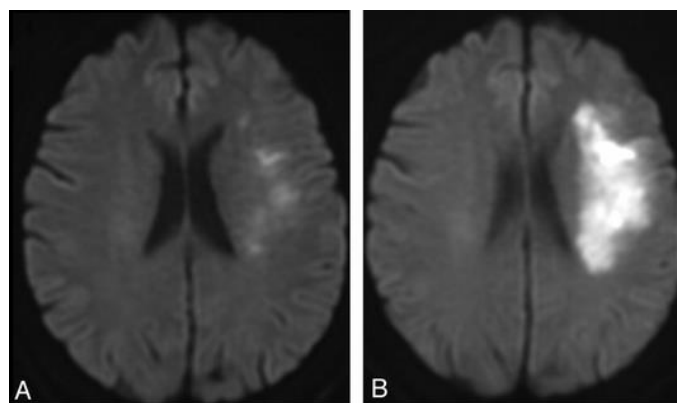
MRI scans of 70 year old woman presenting stroke symptoms, on admission (A) and after an follow up scan after an ischemic event (B). The propagation of damaged area from one picture to another is visible (bright white). Adapted from <http://www.ajnr.org/content/33/3/545/F2.expansion.html>
